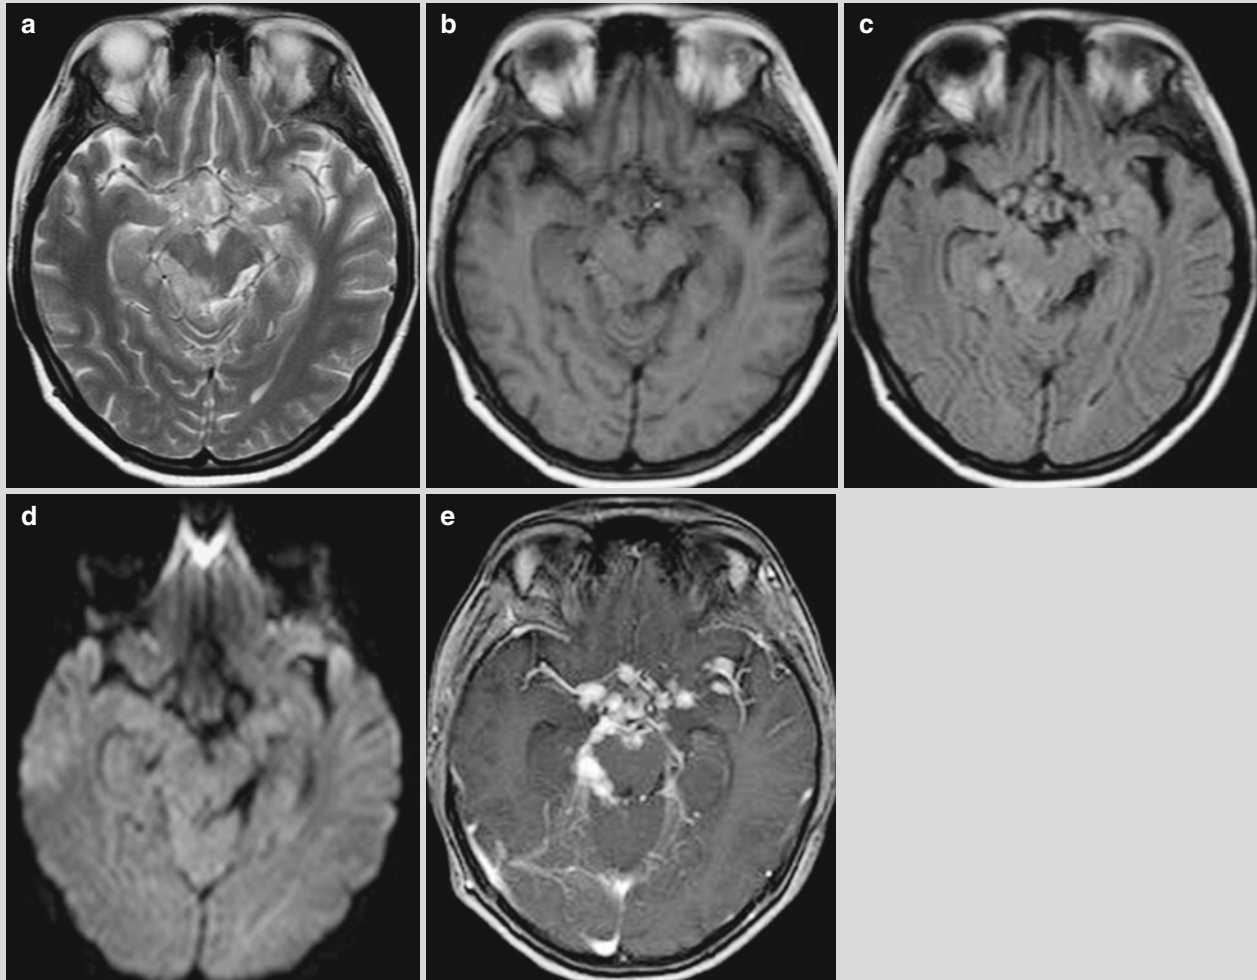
Tuberculous meningitis. (a–e) MR imaging demonstrates obvious thickening of meninges at the suprasellar cistern and quadrigeminal cistern, with low T1WI signal and high T2WI signal.
